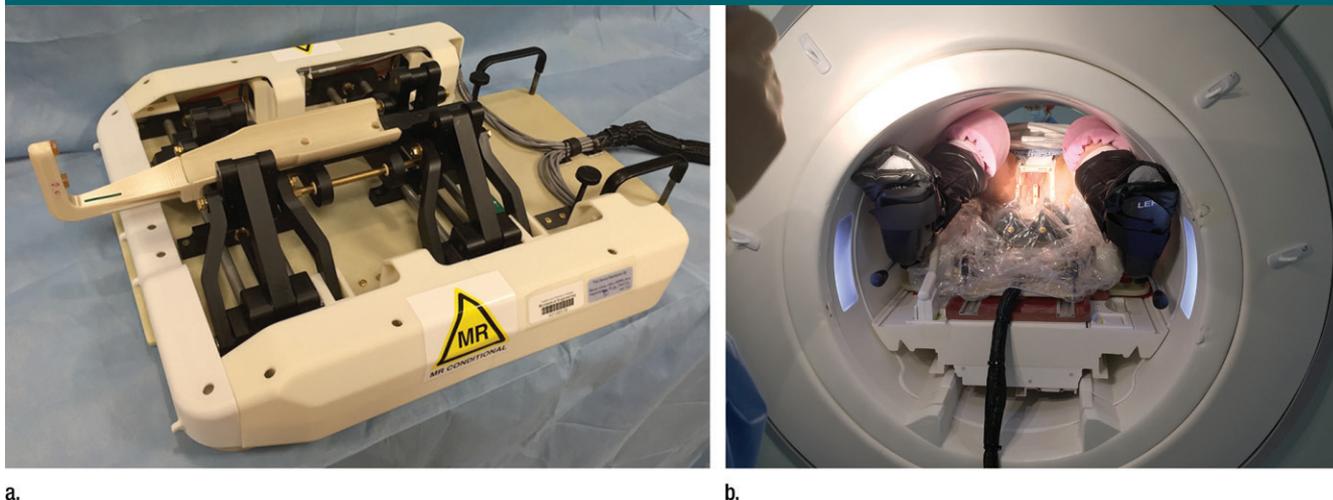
Images show MR imaging–compatible prostate biopsy robot. (a) Transperineal needle placement robot is shown (b) in position between patient's legs in 70-cm bore 3.0-T magnet.
